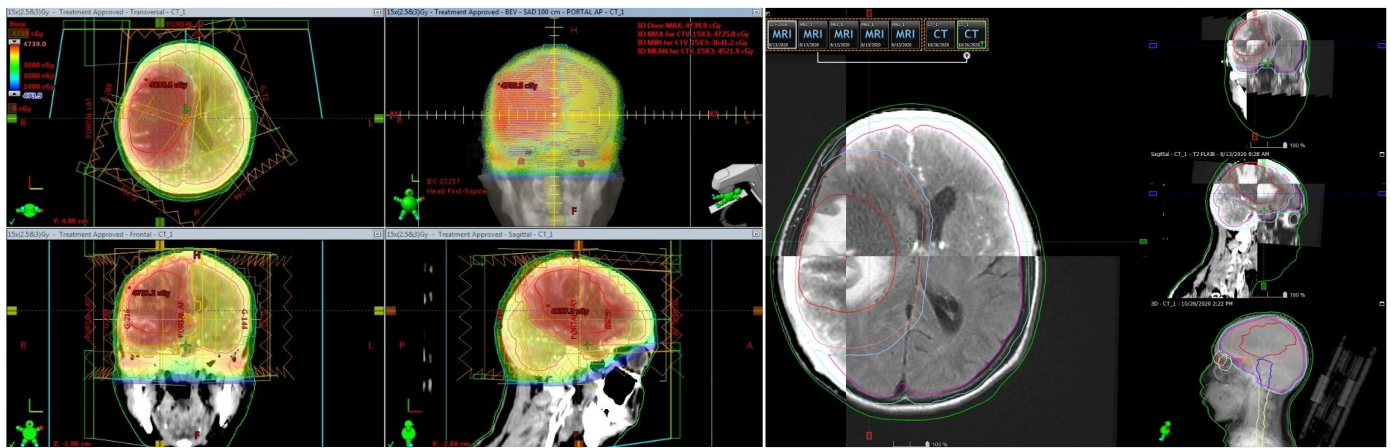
(Left) Planning and (Right) contouring of radiotherapy in patient AN. The contouring picture shows a fused image of CT and MRI view
